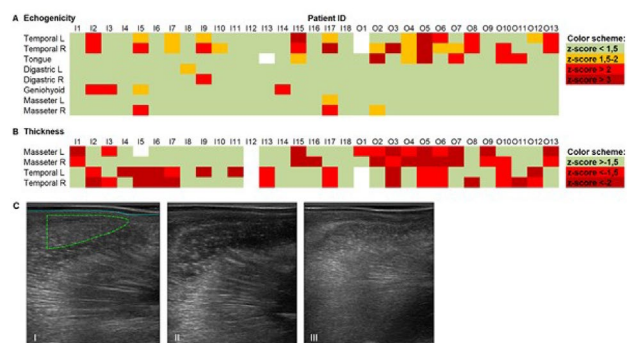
Quantitative muscle ultrasound (QMU) of orofacial muscles in IBM and OPMD patients.
